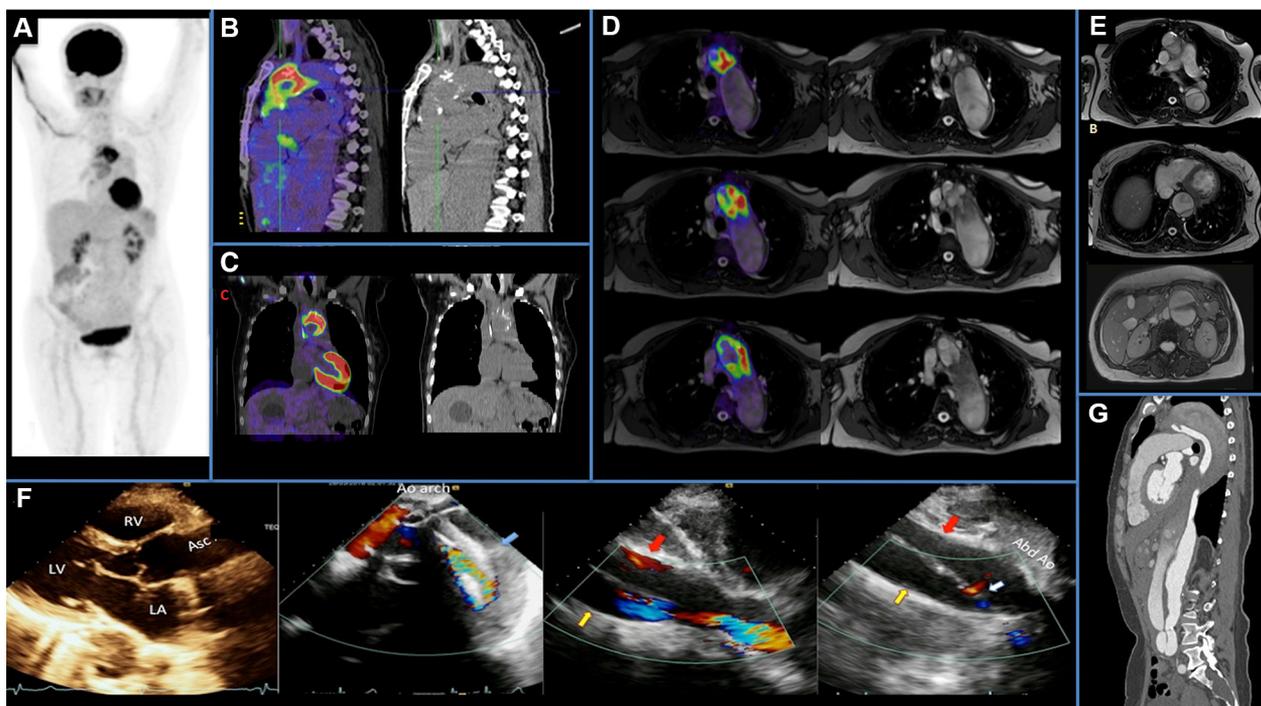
MIP, PET/CT, PET/MRI fusion, MRI, TTE, and CTA. (A) Maximum intensity projection (MIP) on anterior view of whole body ^{18}F -FDG PET/CT. Beside normal ^{18}F -FDG biodistribution, there is an intense uptake on mediastinum over middle line, Online clip A. (B) and (C) Sagittal and coronal ^{18}F -FDG PET/CT show increased uptake on aortic arch graft with SUVmax of 10.92, Online clips B and C. (D) Axial PET/MRI fusion. Both studies were acquired with difference of 2 days, the fusion was done manually. MRI shows slightly aortic wall thickening on the uptake site. (E) MRI axial T2-weighted at thoracic and abdominal levels. Dissection Stanford B was detected from ascending aorta to iliac bifurcation. (F) Transthoracic echocardiogram (TTE). Parasternal long axis of ascending aorta with normal diameters, suprasternal axis of the aortic arch showing aortic dilatation and dissection with thrombosis of the false lumen (blue arrow). Long axis view of abdominal aorta with dilatation and dissection. The white arrow points the reentry between false (red arrow) and true lumen (yellow arrow), Online clips F-1–4. (G) Sagittal aortic computed tomography angiography (CTA). Dissection flap is observed that starts at the level of the sinuses of Valsalva and extends before iliac bifurcation, with a reentry zone (17 mm diameter) at aortic arch level and other one smaller at the origin of celiac trunk. Aneurysmatic dilatation of the descending and abdominal aorta with increased growth rate (current 57 mm, previous 34 mm), Online clip G.
